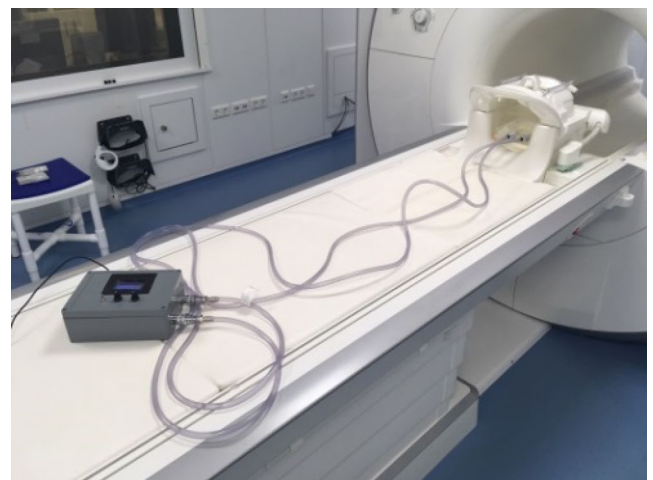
Experimental setting in MRI
